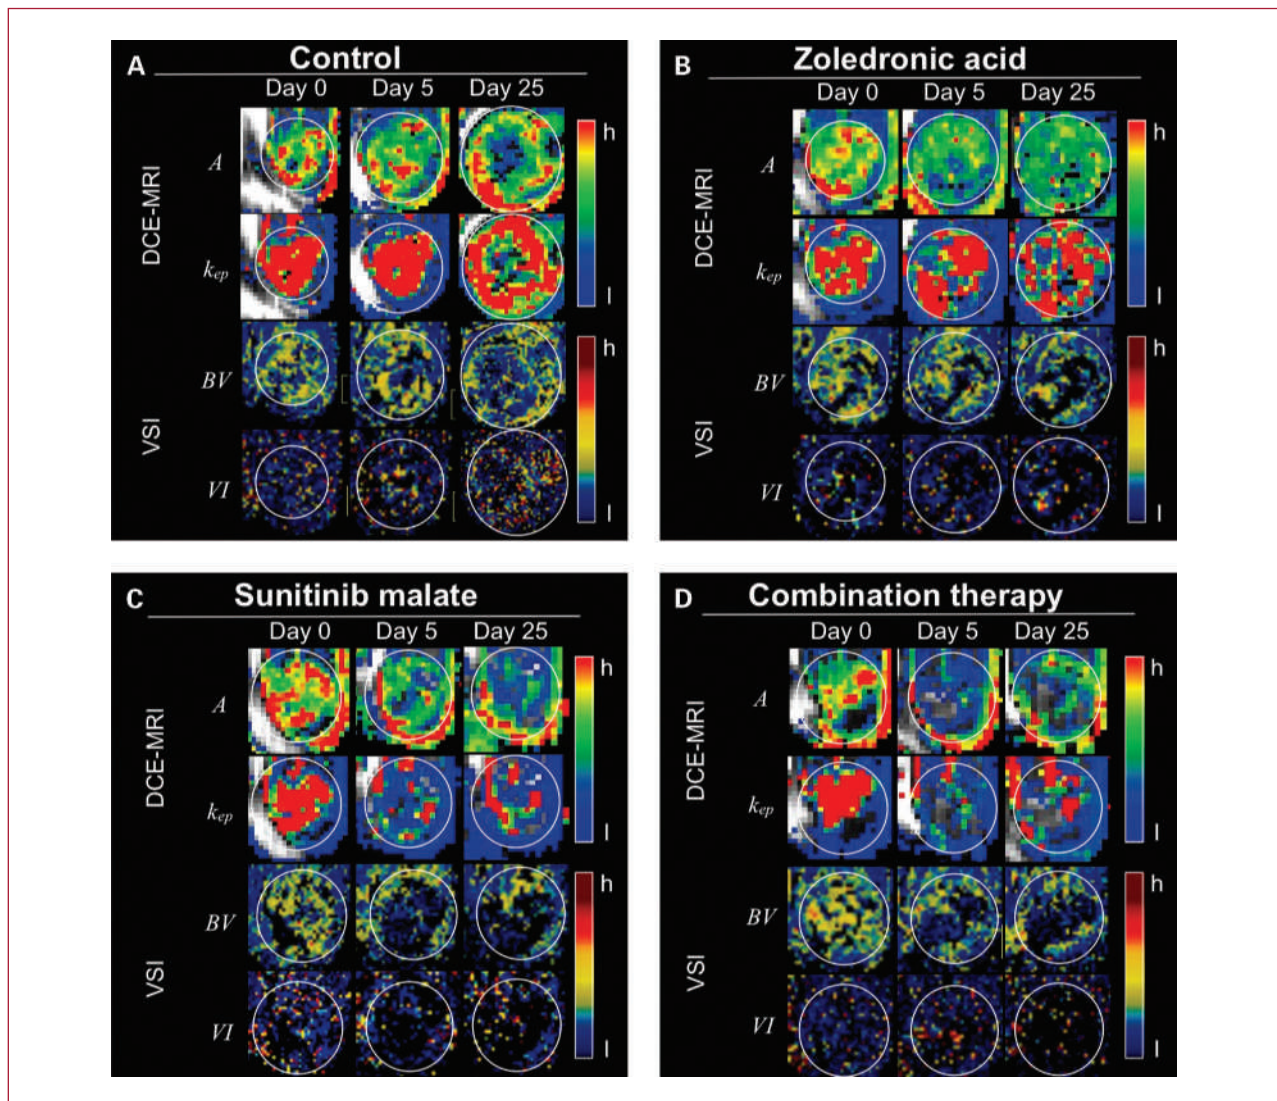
A to D, color maps of experimental bone metastases as imaged by DCE-MRI and VSI at days 0, 5, and 25 (A, untreated control; B, treatment with ZA; C, treatment with SM; D, combination therapy). First rows, A; second rows, k_{ep} ; third rows, BV; fourth rows, VI. Color maps in axial orientation (white circles delineate bone metastases) for all parameters ranging from high (h; red) to low values (l; blue).
